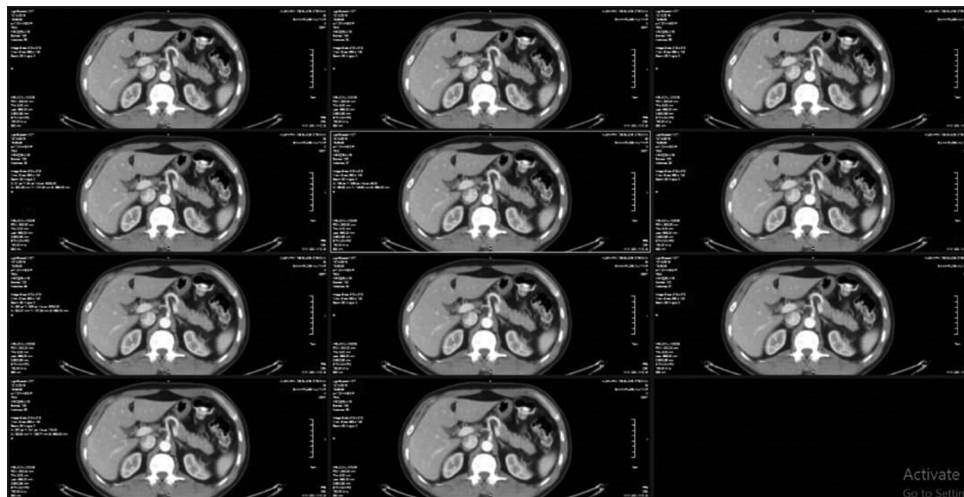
Transverse abdominal computed tomography images of a 40-year-old patient. Images were reconstructed with filtered back projection or adaptive statistical iterative reconstruction from 0% to 100%
